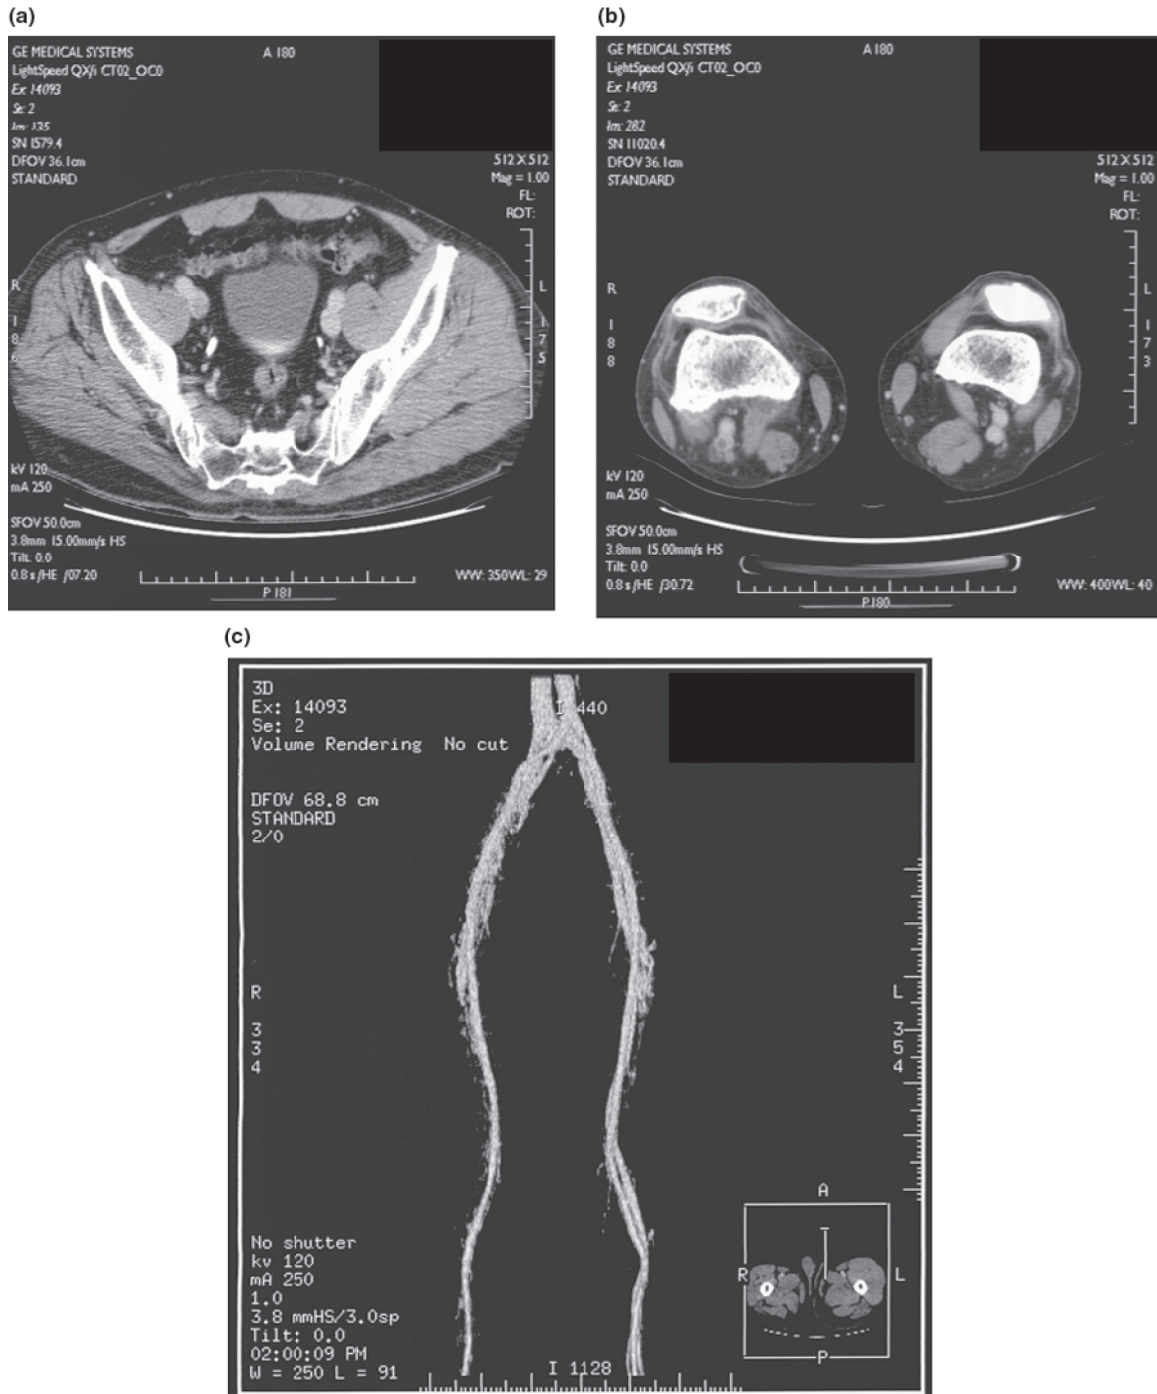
Lower extremity computed tomographic angiogram shows the deep vein thrombosis extending from the right iliac vein (a, c) to this tibial vein (b, c).
